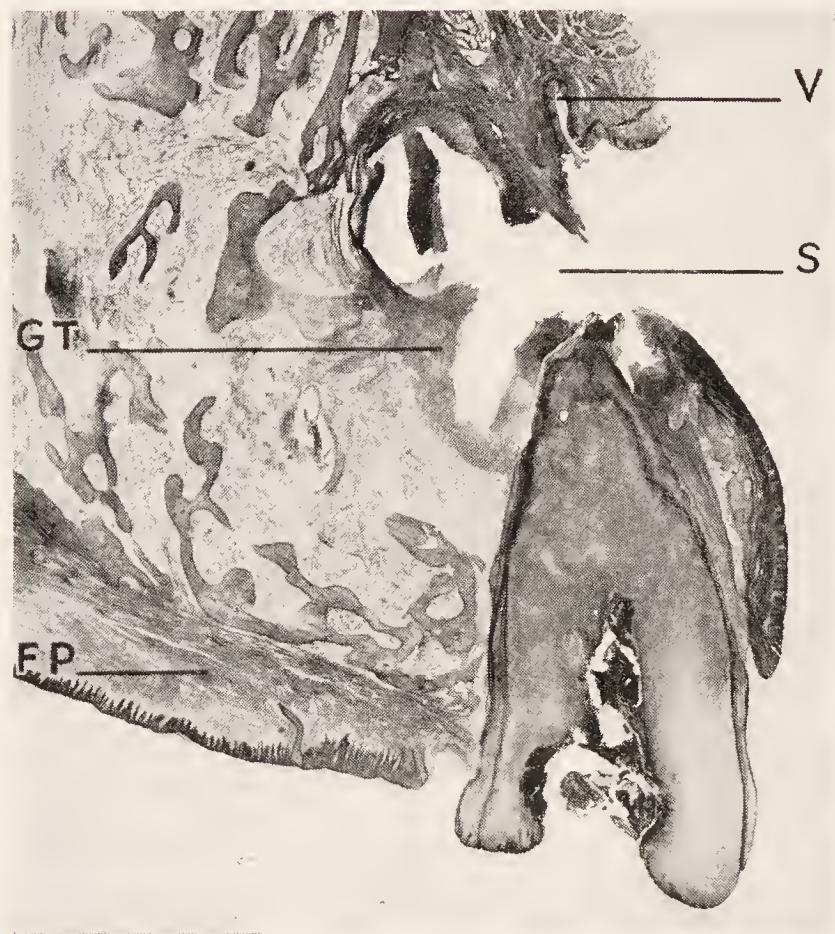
Chronic periapical inflammation with formation of a sinus. Bucco-lingual section through a buccal root of a broken-down upper first molar. At the root end an abscess cavity has formed from which a sinus leads into the buccal vestibulum. V, vestibulum (point of reflection of the mucosa of the cheek); S, sinus; GT, granulation tissue forming the wall of the abscess cavity; FP, fibrous tissue of the hard palate.
